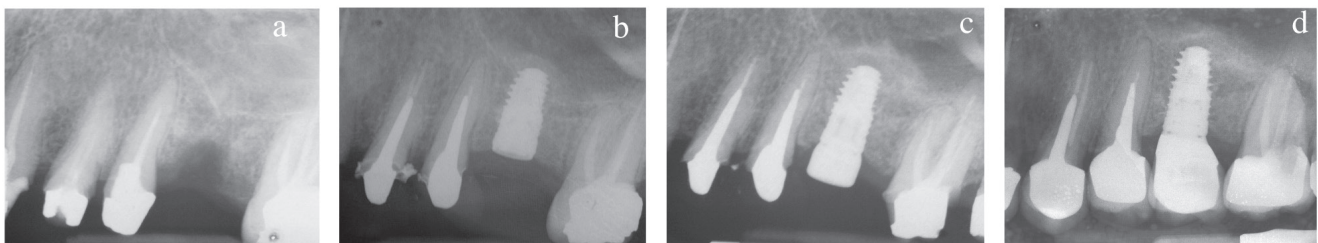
Consecutive radiographs showing graft consolidation and the formation of new sinus floor. a: pre-operative; b: after surgery; c: at 2nd stage surgery (6 months); d: at twelve months (D0, D6 and D12)..
